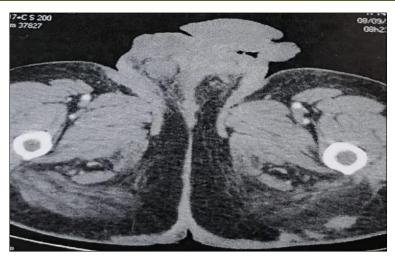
(A) Large nodular perineogenital mass; (B) CT scan of the mass
